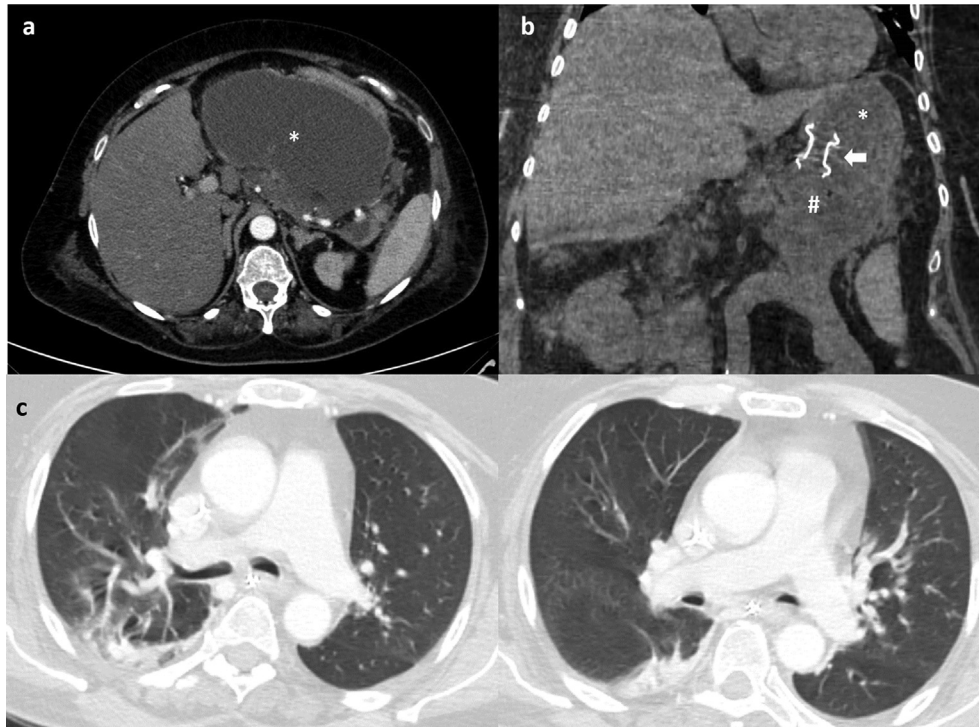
Abdominal CT scans showing (a) the large pancreatic pseudocyst measuring 16 cm × 8 cm × 12 cm (*) and (b) the Lumen Apposing Metal Stent (white narrow) placed transmurally between stomach (*) and pancreatic pseudocyst (#). (c) Chest CT scan showing bilateral and multiple mottling and ground glass opacities compatible with SARS-CoV2 associated pneumonia.
